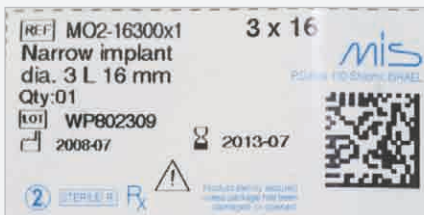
Implant information, implants inserted, postoperative X-ray control and ball anchors attached.
